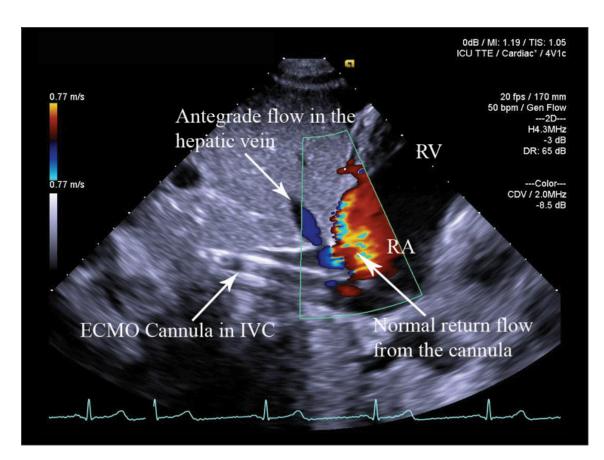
TTE: Subcostal window. Long-axis IVC plane. Color Doppler Mode. Normal antegrade flow in the hepatic vein and adequate right atrial return flow from VV ECMO cannula.
